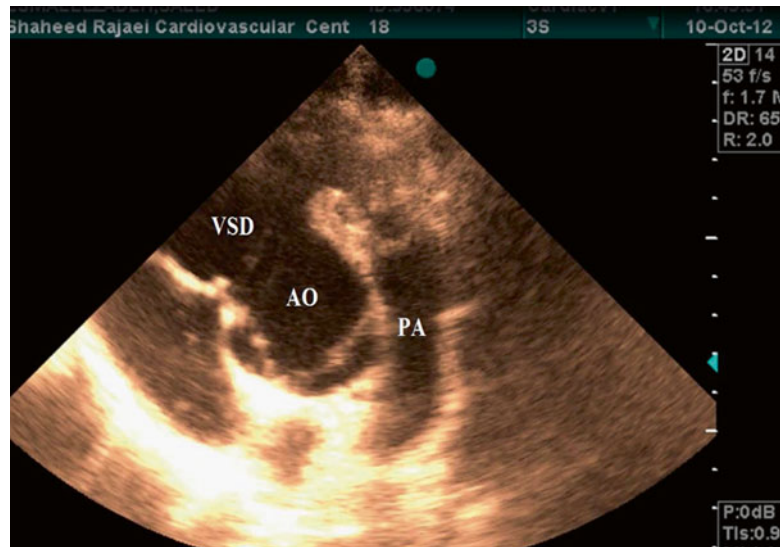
Typical parasternal short-axis view in TOF patient showing anterocephalad deviation of outlet septum with narrow RVOT and large subaortic VSD. PA pulmonary artery, AO aorta, VSD ventricular septal defect
